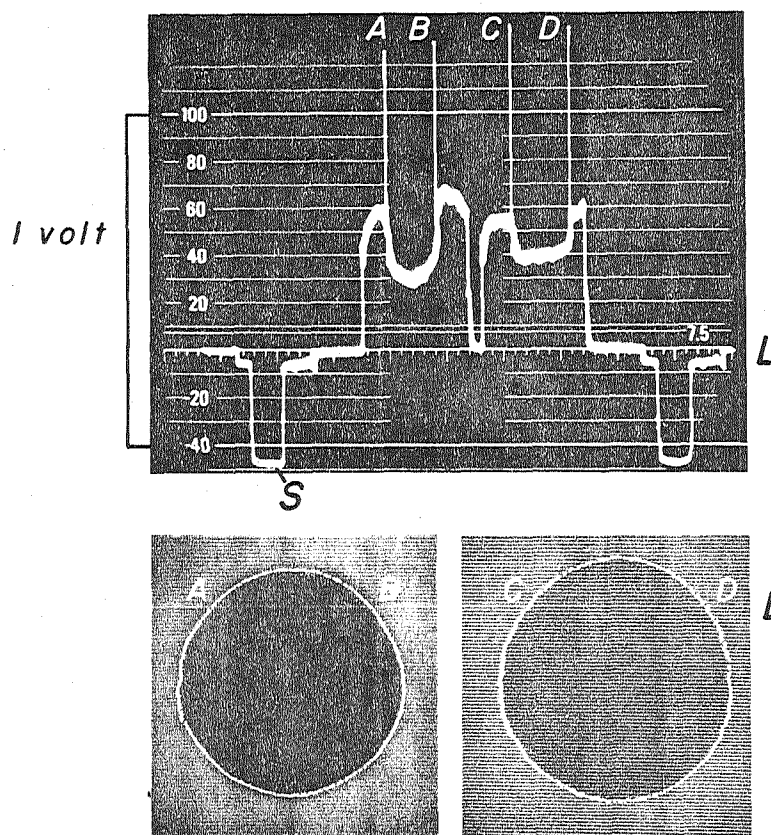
The lower panel shows one frame of biplane videoimages of the radio-opaque calibration sphere as it was played back in stop action from a video disc recorder. The brightened line indicates the video line for which the voltage is displayed on the oscilloscope in the upper panel. A, B, C and D on the video signal and on the biplane image indicate the points at which the line crosses the calibration sphere. These points were recognized by a voltage level sensing circuit and were brightened on the monitor to indicate to the observer where the borders were detected. The borders may be adjusted by adding various voltages to the original signal, independently correcting for any unequal biases in the two systems as frequently results from unequal background x-ray illumination due to varying chest thickness in the case of ventriculograms.
